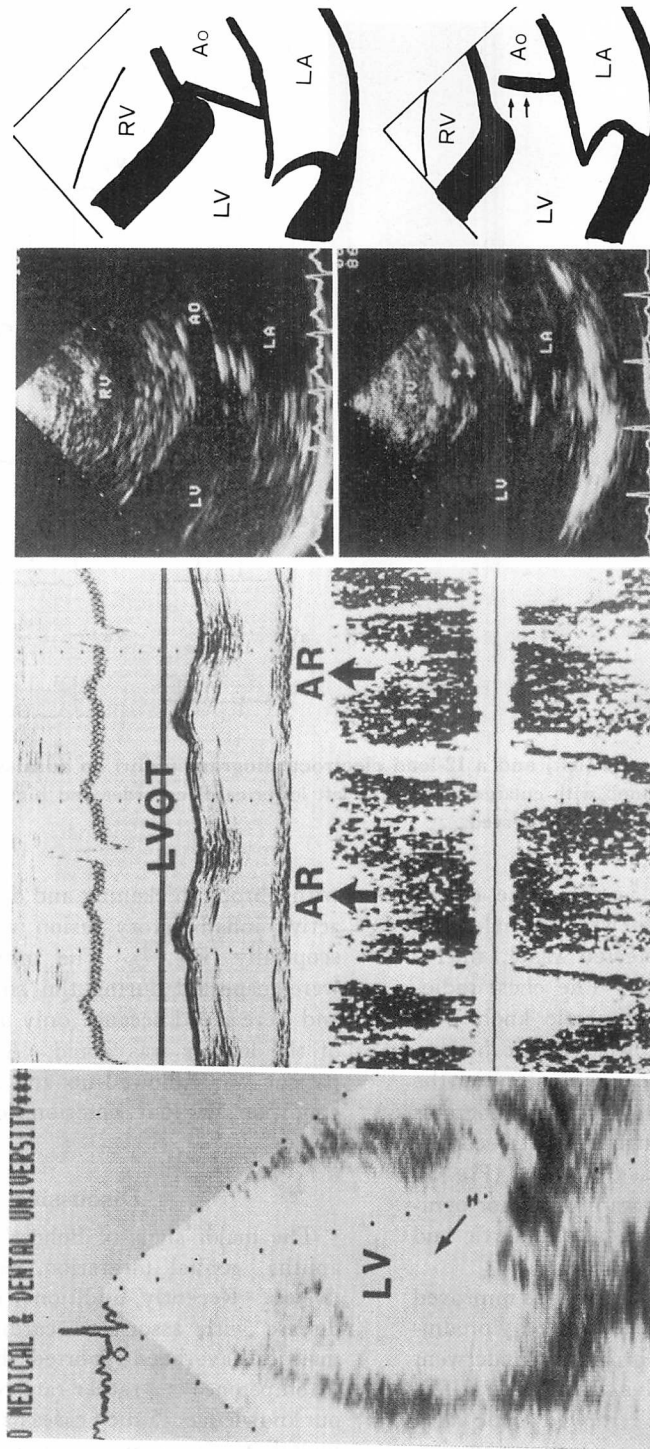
Echocardiograms of Case 1 six months after the initial surgery.
